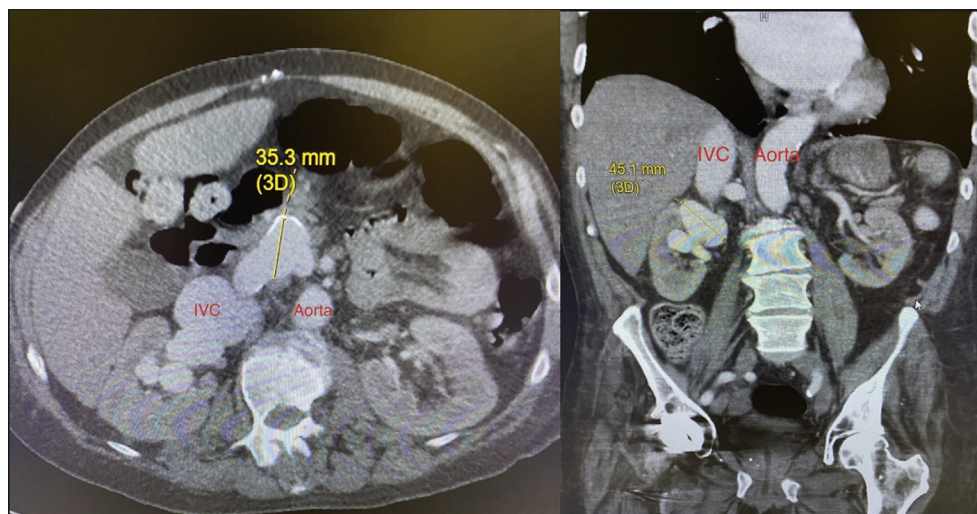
Axial view of computed tomography angiography (CTA) of the abdomen and pelvis depicting a 35.3-mm renal artery aneurysm (RAA) coming off of the aorta (left). Coronal view of CTA of abdomen and pelvis depicting a distal 45.1-mm RAA nearby the renal hilum (right). IVC, Inferior vena cava.
